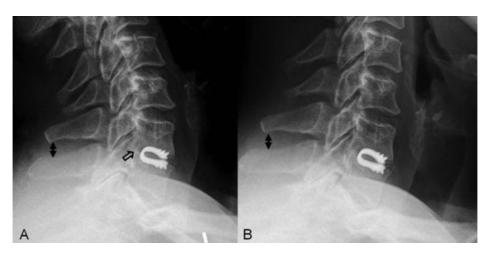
Fusion after dynamic cervical implant surgery on the C6-C7 segment at the 12-month follow-up. Lateral radiographs in (A) extension and (B) flexion revealed constant distances between the C6 and C7 spinous processes (black arrows) and the bony trabeculae behind the implant (open
